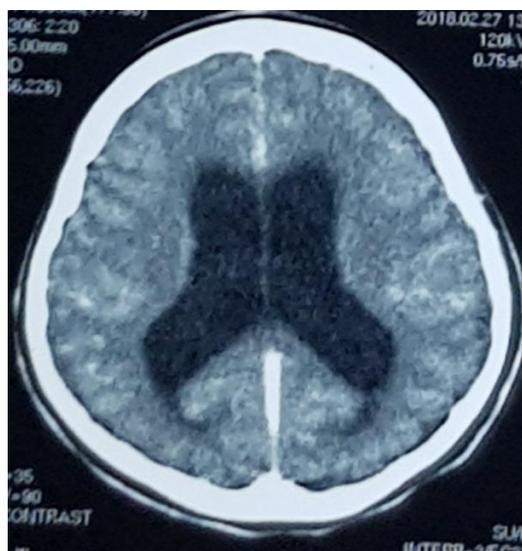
CT-Brain showed dilated both lateral ventricles
